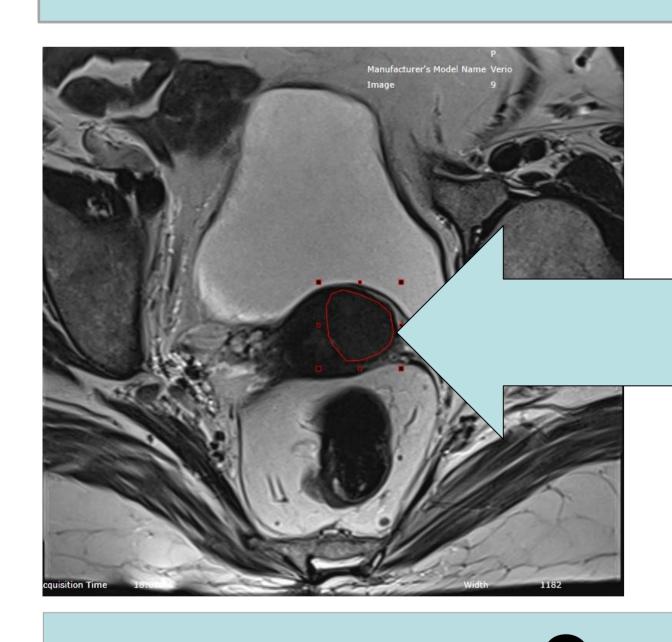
Region of interest(ROI) was drawn on Small FOV T2 transverse MRI image
